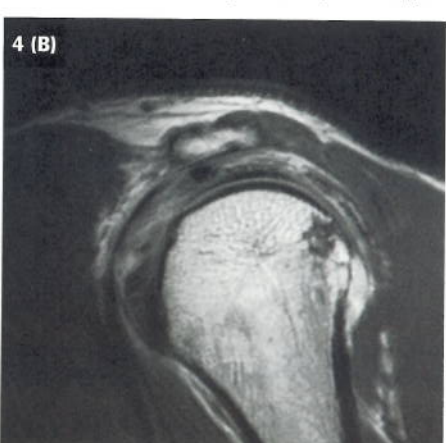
Post-contrast T1-weighted arthrogram images. (A) Coronal oblique. (B) Sagittal oblique.
